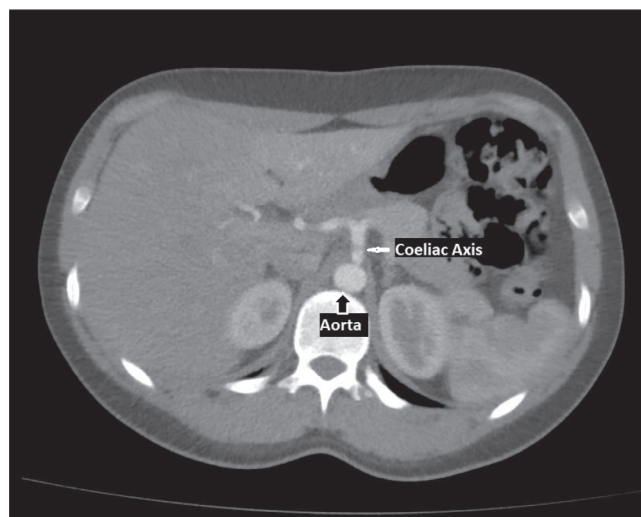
Computed tomography angiography of abdomen, axial plane at the level of the coeliac axis origin.
